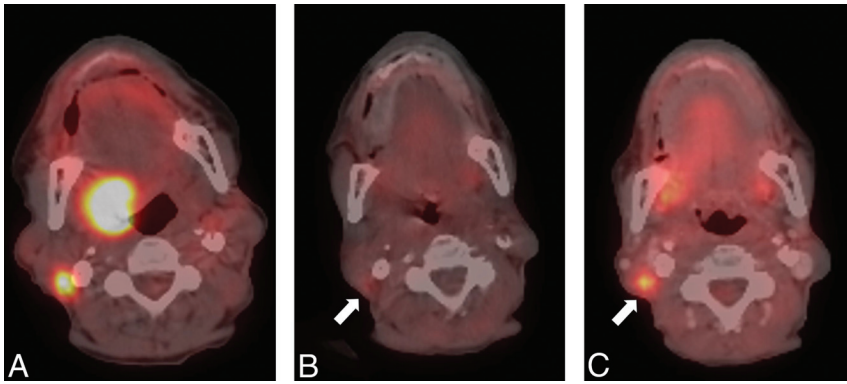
Patient 8. A 69-year-old woman with advanced oropharyngeal squamous cell carcinoma. A, Pretreatment PET/CT shows a large FDG-avid right faucial tonsil and lateral oropharyngeal wall tumor with an FDG-avid right level II nodal metastasis. B, At 8 months after completion of therapy, there is complete response of the primary tumor but mild residual FDG uptake in the treated right level II node. C, Surveillance PET/CT scan obtained at 16 months after treatment shows increased FDG avidity and size of the right level II node, consistent with regional treatment failure, confirmed by salvage neck dissection. There is no disease recurrence at the primary tumor site.
